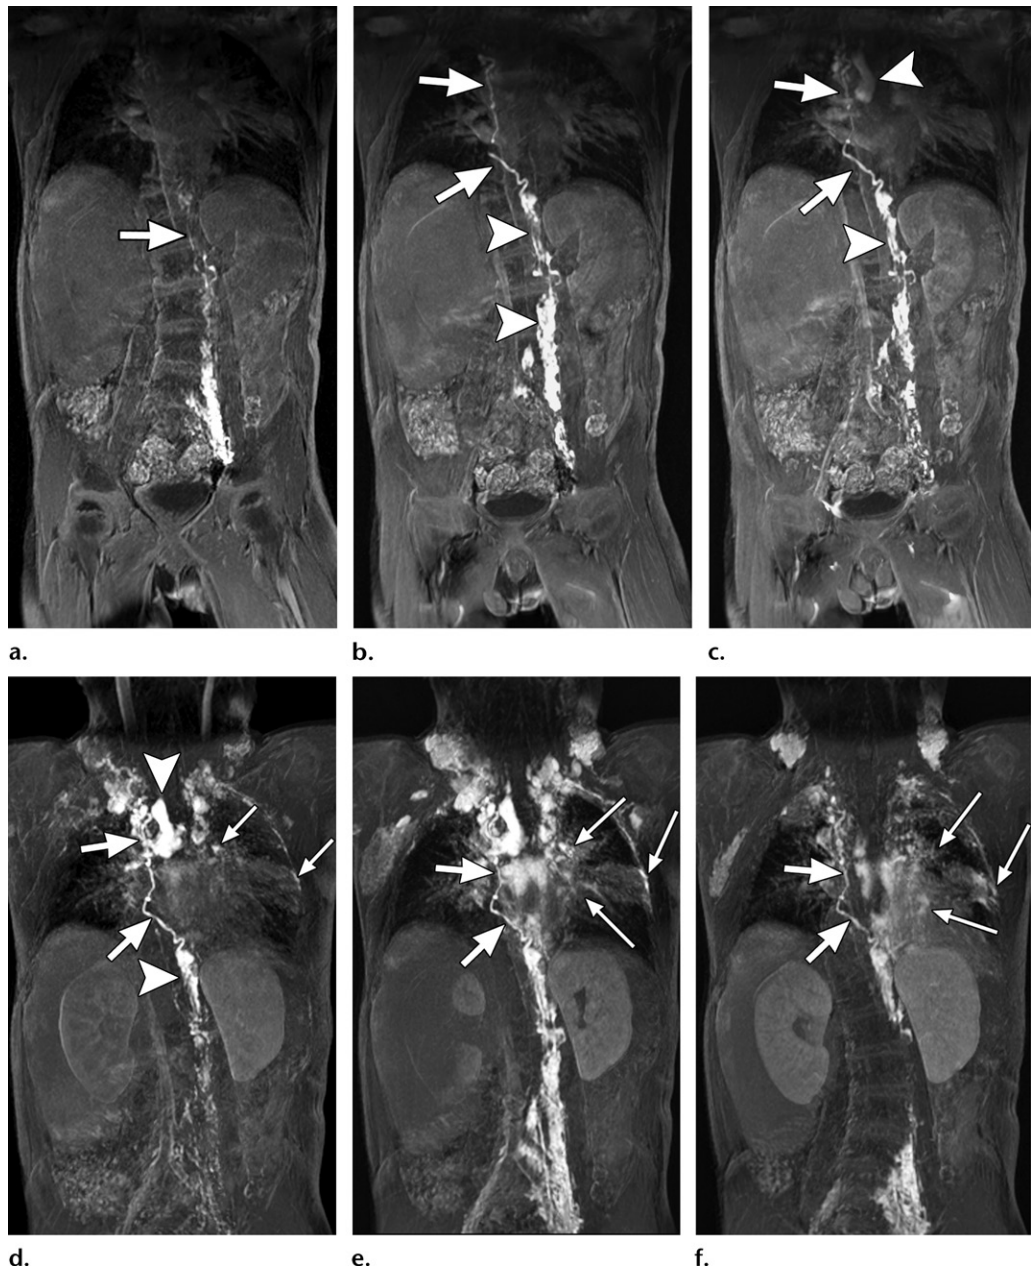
MR lymphangiography in an 8-year-old child with a history of Fontan surgery and plastic bronchitis. Coronal 3D T1-weighted images with thin MIP reconstruction at 2 (a), 4 (b), 6 (c), 8 (d), 10 (e), and 20 (f) minutes after injection of contrast material demonstrate an abnormal lymphatic duct extending from the retroperitoneum to the right side of the superior mediastinum (thick arrows), lymphangiectasia in the retroperitoneum (arrowheads) and mediastinum (arrowheads), and extensive and progressive chylolymphatic reflux into cervical and axillary lymph nodes. There is no clear visualization of a typical thoracic duct. The delayed images (e, f) also demonstrate chylolymphatic reflux into the left lung, pleural region, and right lung apex (thin arrows) suggesting pulmonary lymphatic perfusion syndrome (PLPS) as the cause of the plastic bronchitis.
